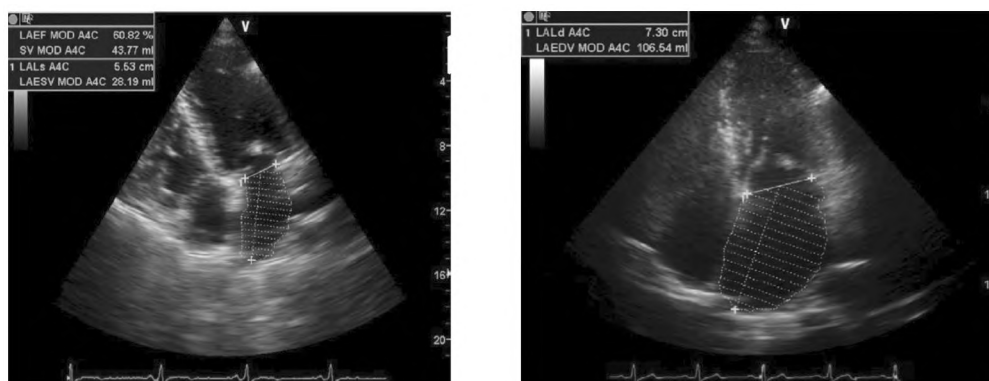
Left atrial (LA) assessment. LA volume was measured from B-mode recordings in apical 4-chamber view (left) and 2-chamber view right.
